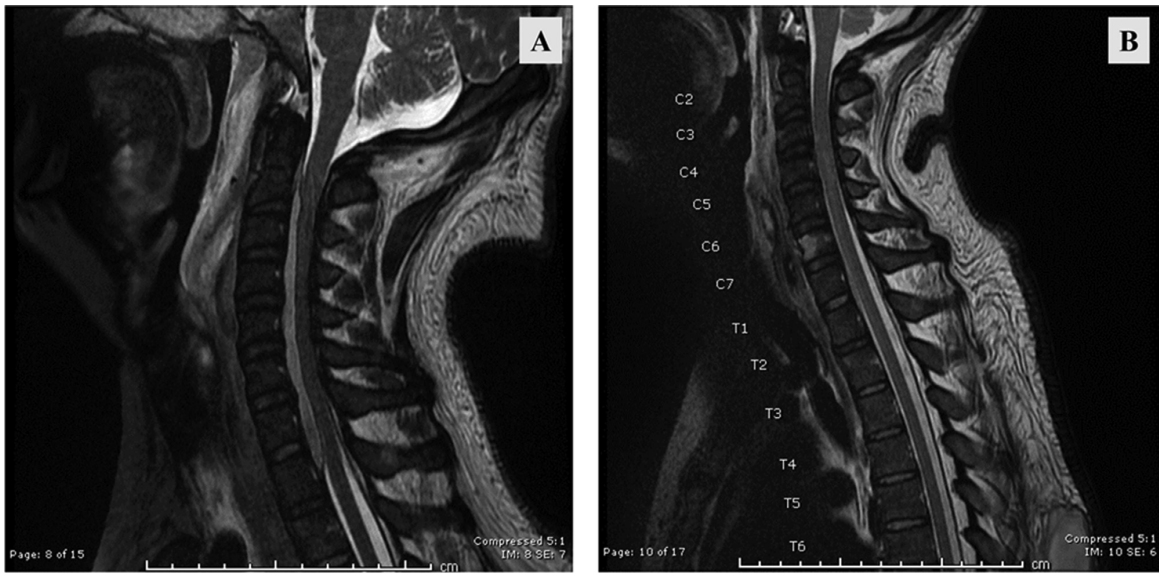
Preoperative T2W-MRI showing a profound retropharyngeal abscess with long-span ventral cervical epidural abscess from C2-T1 (A). An immediate postoperative T2W-MRI showing significant reduction of pus collection at the anterior epidural space (B)
